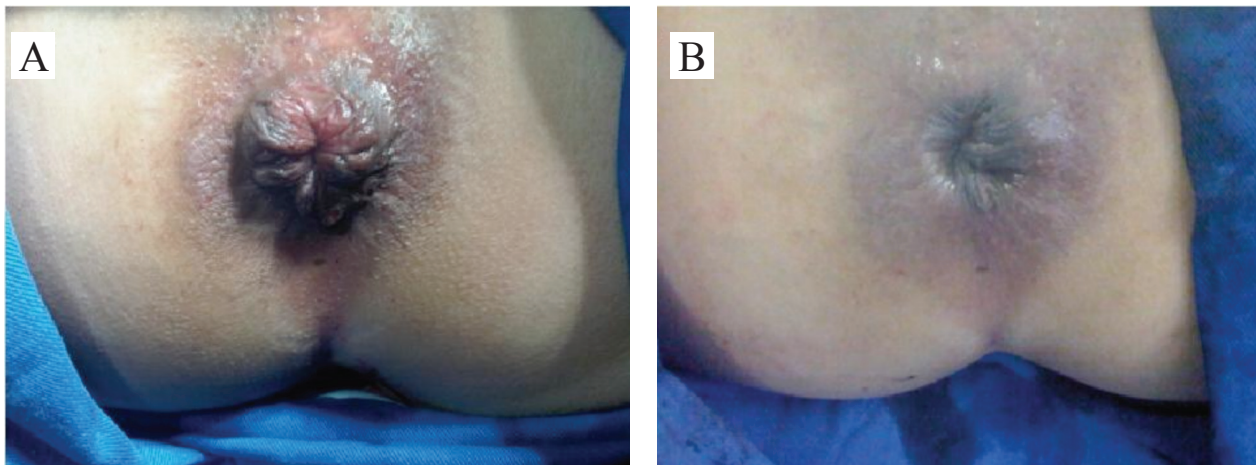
(A) Preoperative aspect of patient with hemorrhoidal disease. (B) Immediate postoperative of the same patient submitted to the doppler-guided transanal hemorrhoidal dearterialization with mucopexy.
